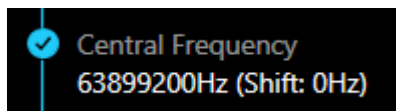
Detected MRI Frequency Frame
